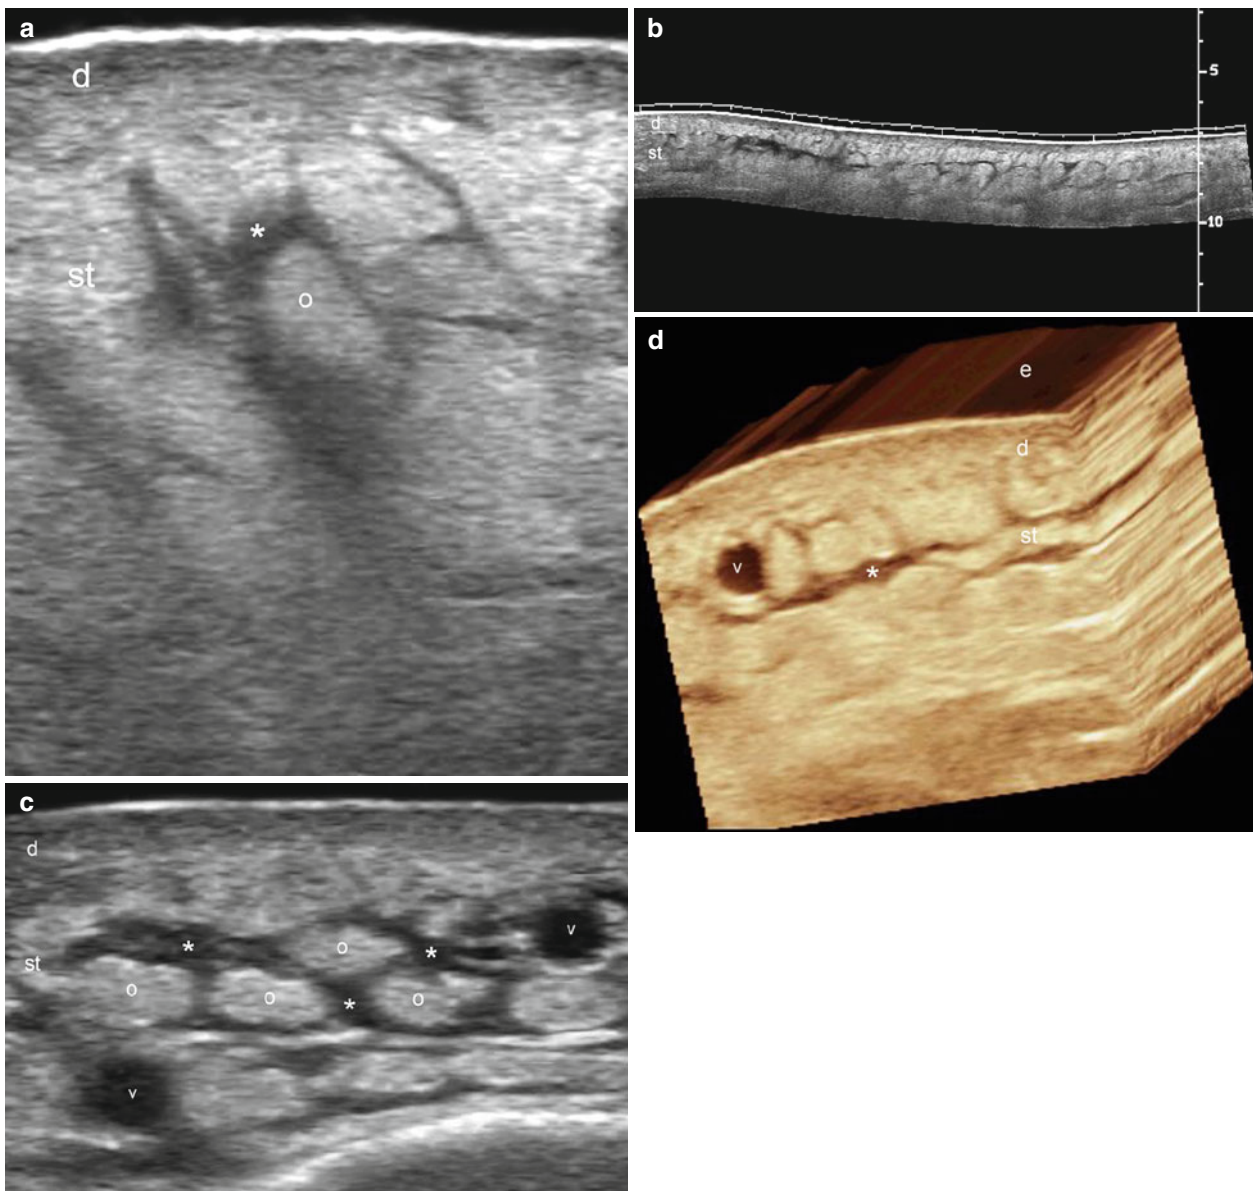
(a–d) Cutaneous edema. Variable sonographic representations of cutaneous edema that show thickening and decreased echogenicity of the dermis and increased echogenicity of the fatty lobules (o) of the subcutaneous tissue. Notice the hypoechoic or anechoic fluid (*) in between the fatty lobules. Blurring of the borders of the lobules can be
